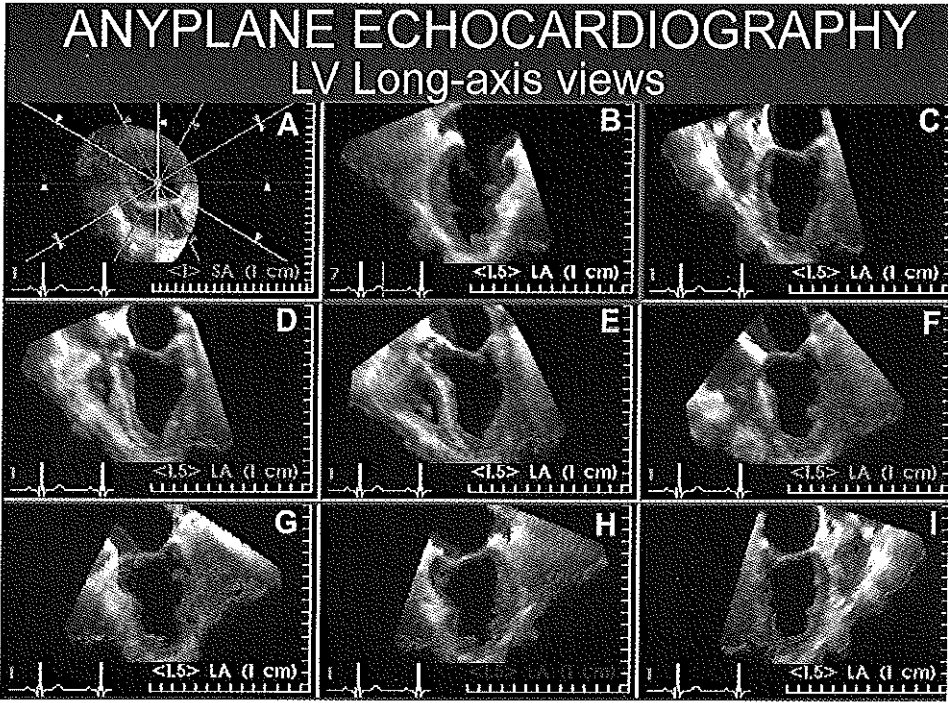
Anyplane echocardiography. From the three-dimensional data set up to 8 cut planes can be selected and reconstructed by computer. In this example left ventricular (LV) long-axis views are generated (panels B-I) and their orientation is shown in panel A. A comprehensive standardized analysis of the shape, size and wall motion of the left ventricle is possible.
